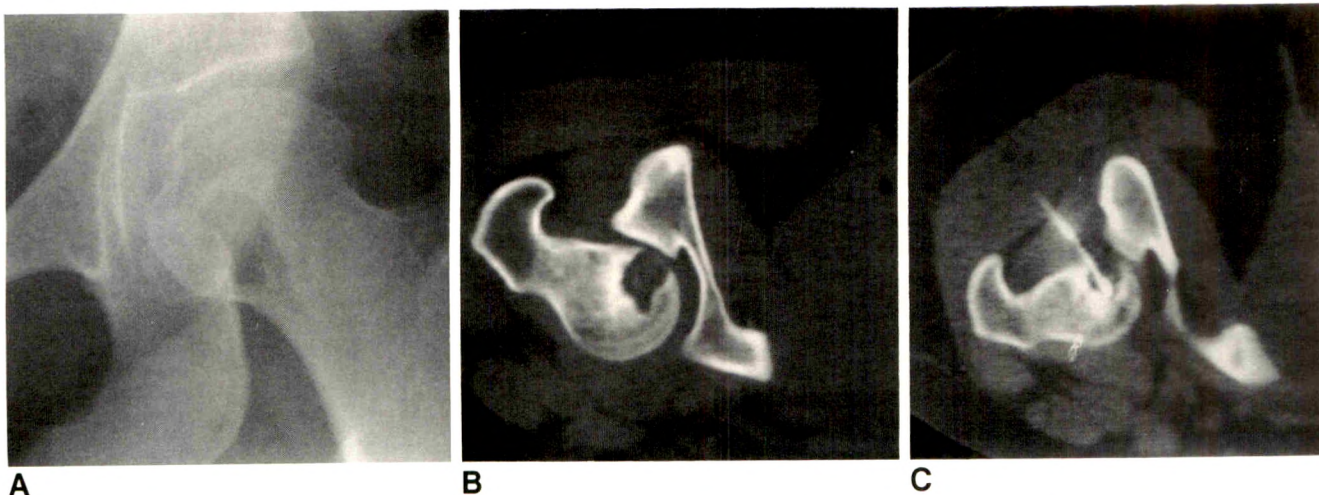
A, Anteroposterior plain film of hip shows a lytic lesion in medial femoral head. Appearance might suggest that this lesion is easily accessible, if femoral vessels can be avoided.
